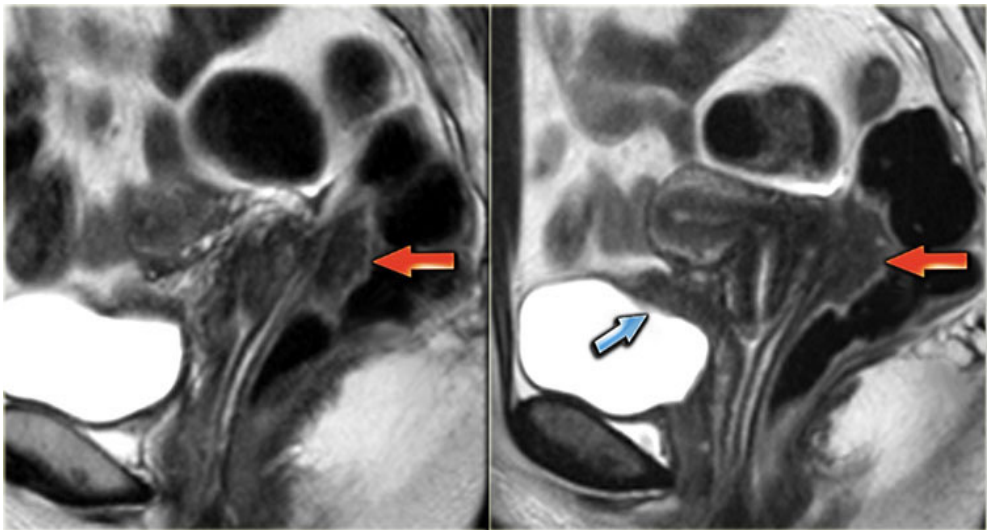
Endometriosis MRI detection – Cullen's syndrome (82)
